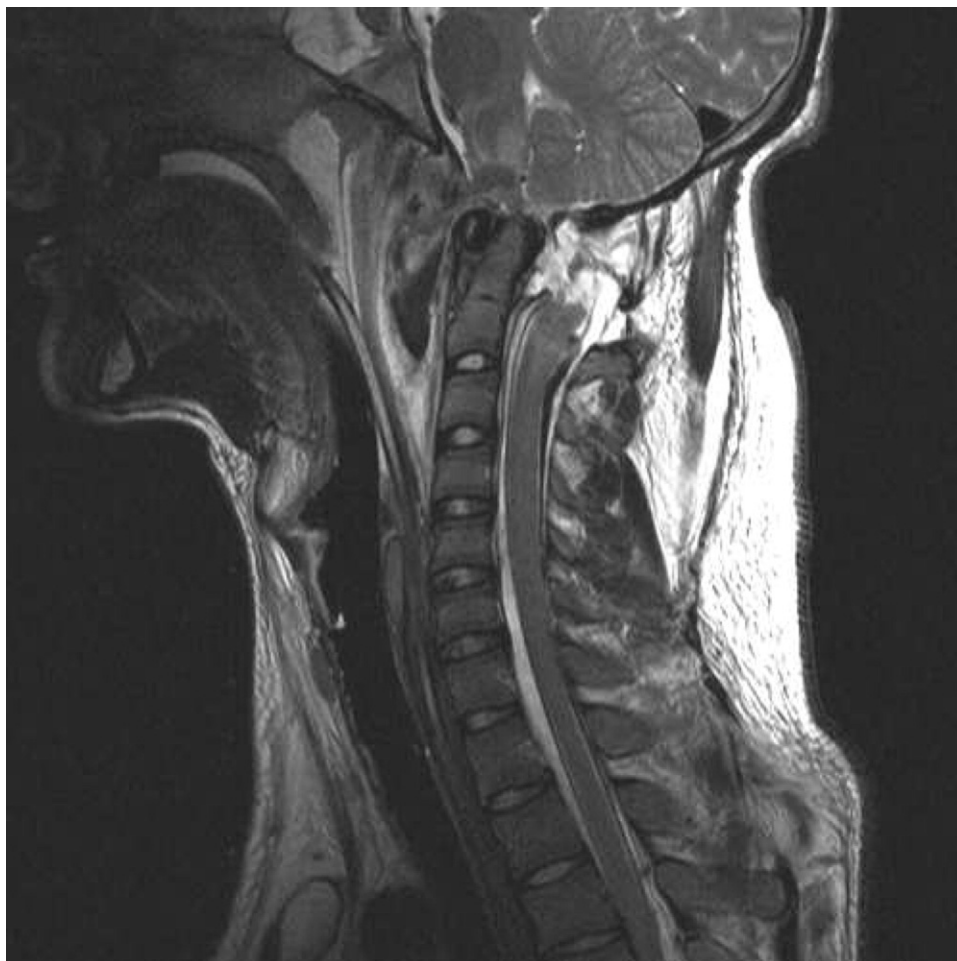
Mid-sagittal T2-weighted magnetic resonance image of the cervical spine. Used with permission of Oliver P. Gautschi, MD, Department of Orthopaedic and Trauma Surgery, Royal Perth Hospital, Perth Western Australia, Australia.
